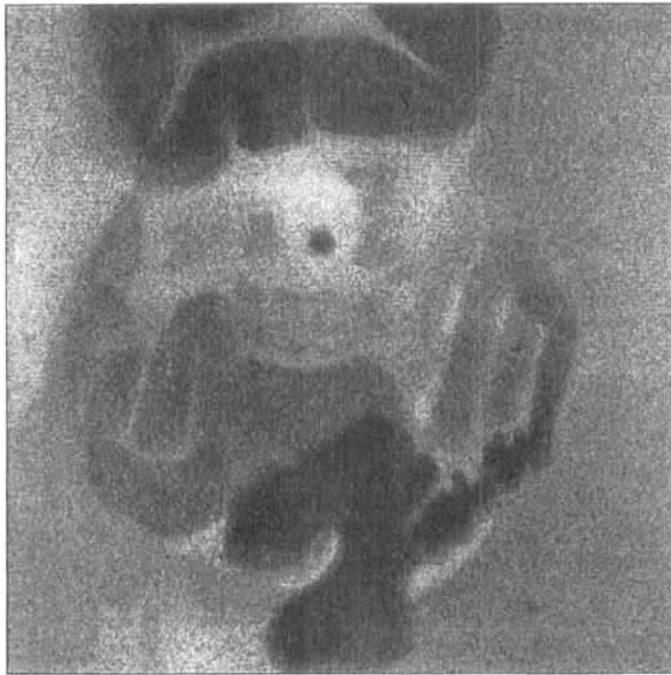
X-ray photograph to show several shadows thrown by diverticula of the sigmoid after barium injection. (*Case 31.*)
